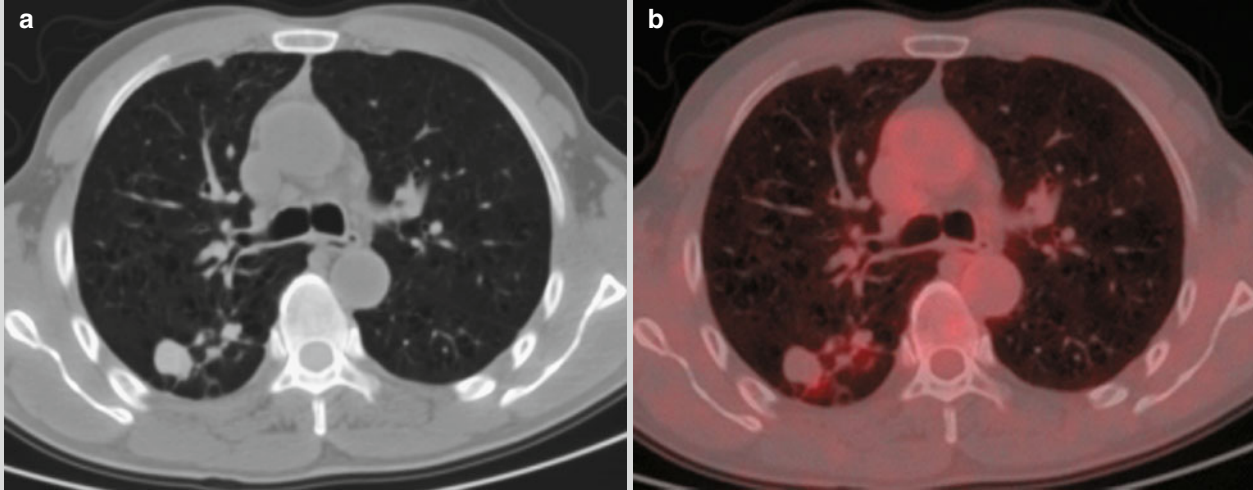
Pulmonary TB. (a) CT scanning demonstrates spots of nodular and cord-like TB lesions at the posterior segment of the right upper lung lobe, with well-defined boundary. (b) The lesion is
